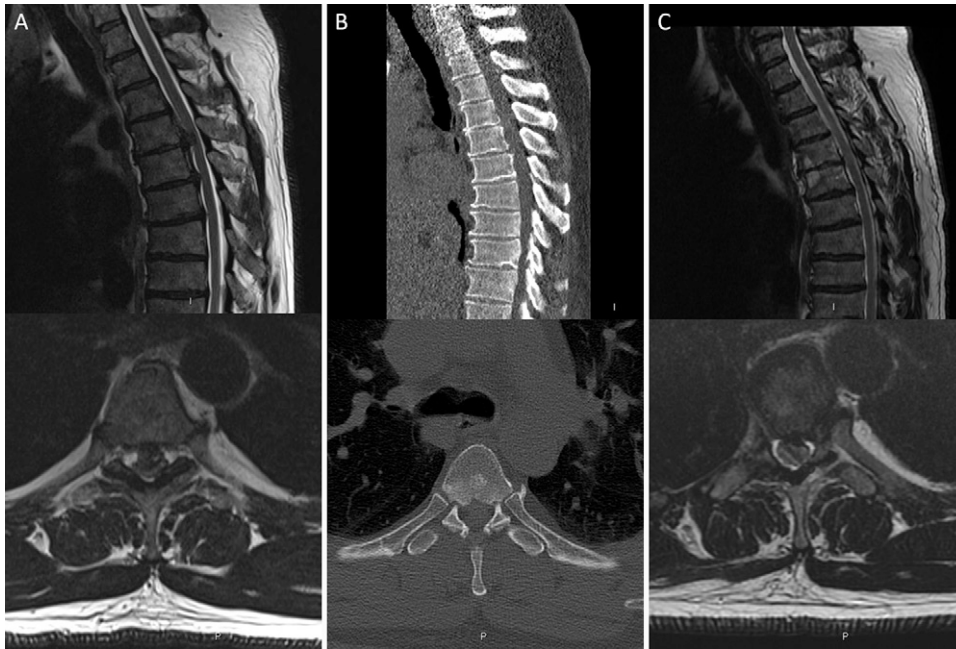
Case 2. A: Preoperative sagittal (*upper*) and axial (*lower*) T2-weighted MRI shows the large central soft tissue disc prolapse causing flattening of the cord. B: Preoperative sagittal (*upper*) and axial (*lower*) CT shows the soft tissue prolapse without calcification. C: Postoperative sagittal (*upper*) and axial (*lower*) T2-weighted MRI shows decompression of the thecal sac and cord.
